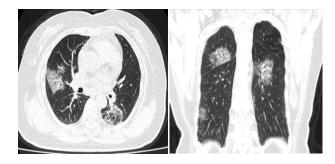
CT Thorax showing multiple patchy peripheral ,bilateral ground glass opacity. ¹³
